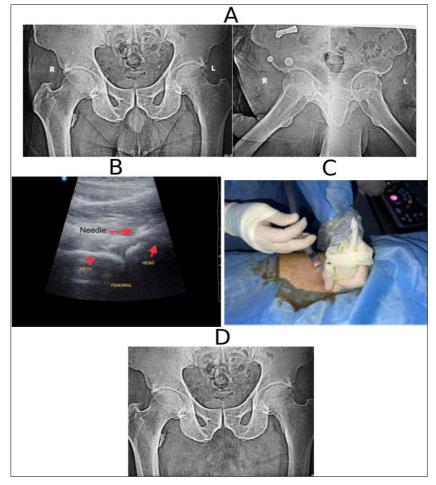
(A): Plain x-ray before the injection showing the osteoarthritis hip kellgnen-Lawrence grade 3 with multiple osteophytes, narrowing of joint space. (B): Ultrasound showing head neck junction. (C): Injection method of "hyalone 60mg/4ml" ultrasound guided. (D): Follow up x-ray after 6 months with insignificant change
